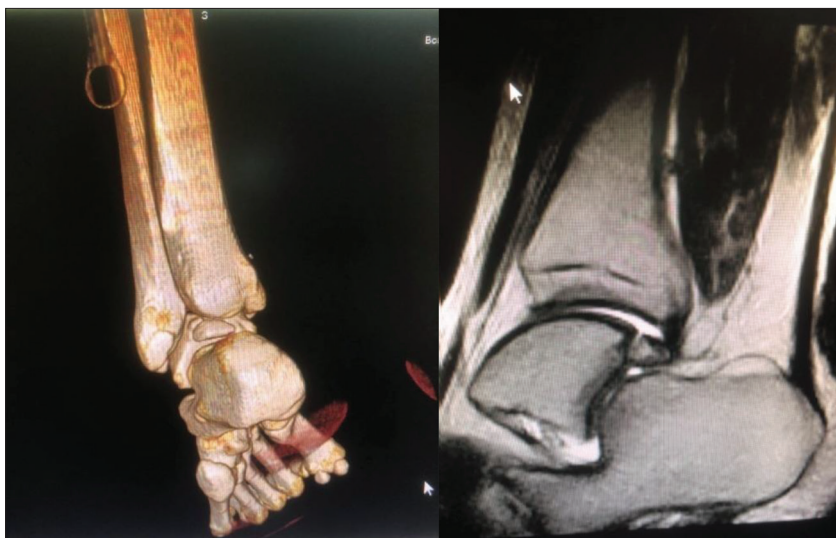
Computed tomography and magnetic resonance imaging showed posterior talar process fracture
